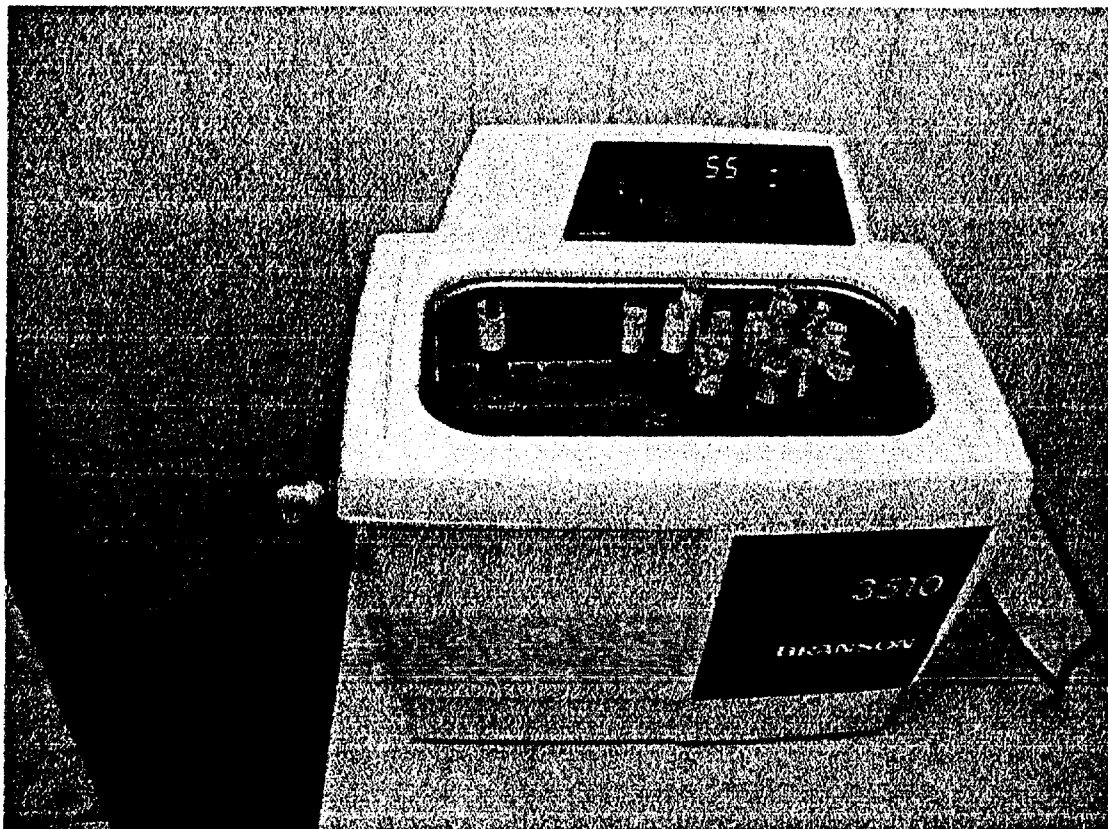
Application of BRANSON 3510 ultrasonic bath for extraction and purification of enamel by the method of chemical etching in alkaline solution. 16 tubes with samples that are simultaneously treated are seen in the present case. Maximum of working places is 56 for shown construction of tube holder.
